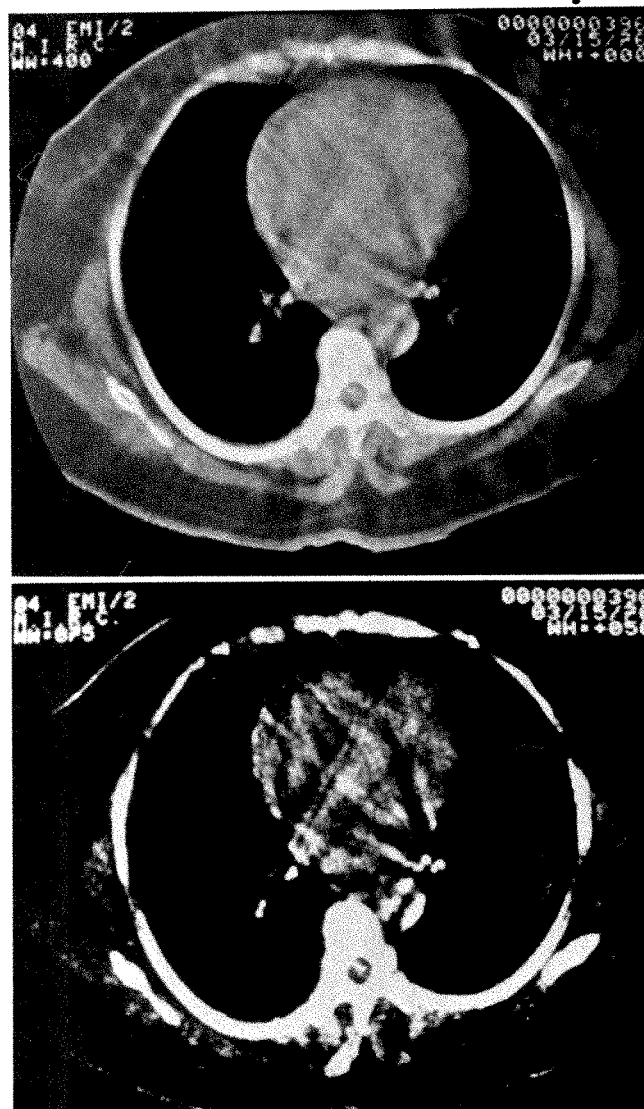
Transmission CT scans of beating human heart. Images differ by window setting. Section thickness 13 mm; scan time 20 sec per section.
